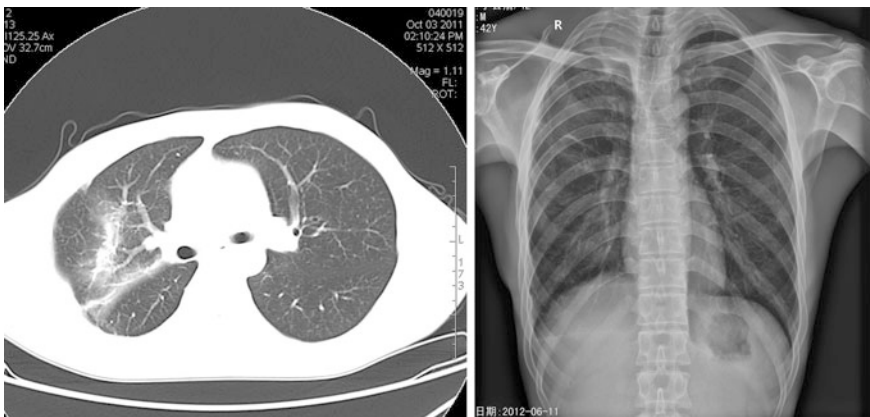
CT or Chest X-ray followed up in 4 weeks and 9 months after removal of intrapulmonary hematoma and surgical pneumonorrhaphy
